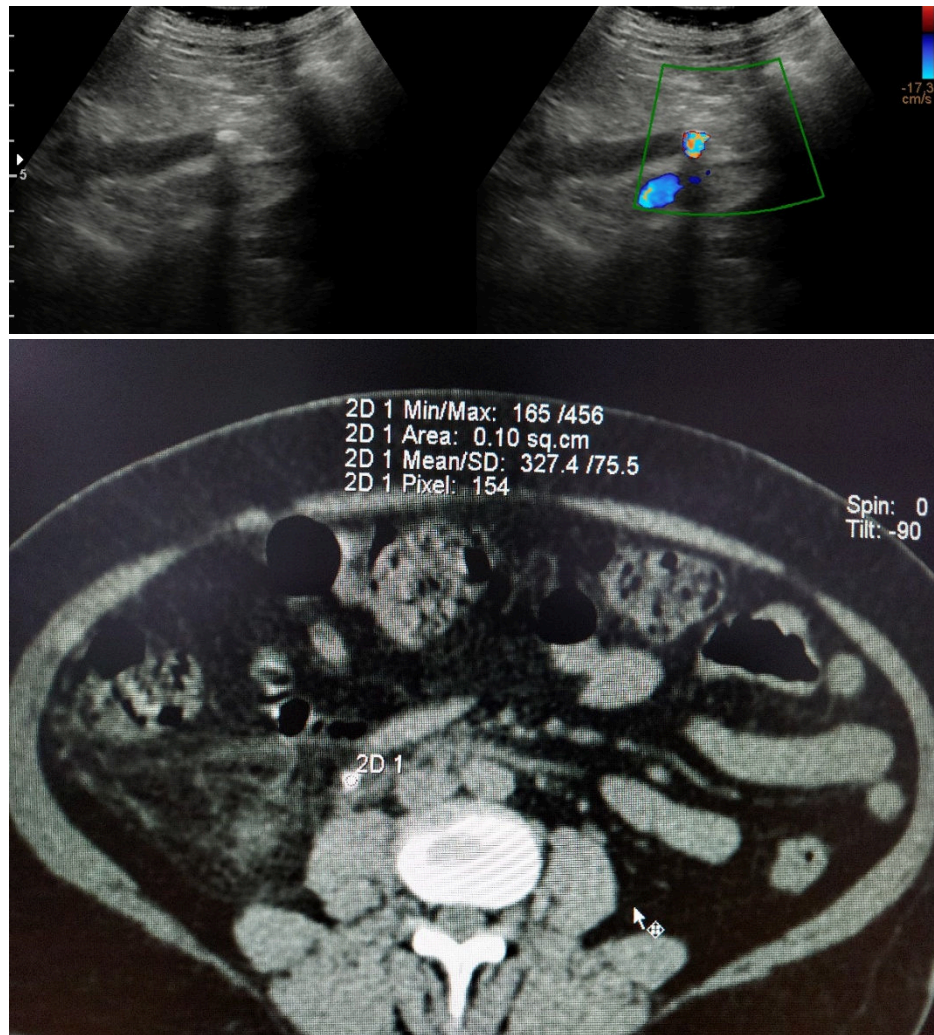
Figure IV (A, B): US (grey scale and colour doppler) as well as non-contrast CT showing calculus in the right proximal ureter which shows grade 3 twinkling artifact on doppler with mean HU of 327.
